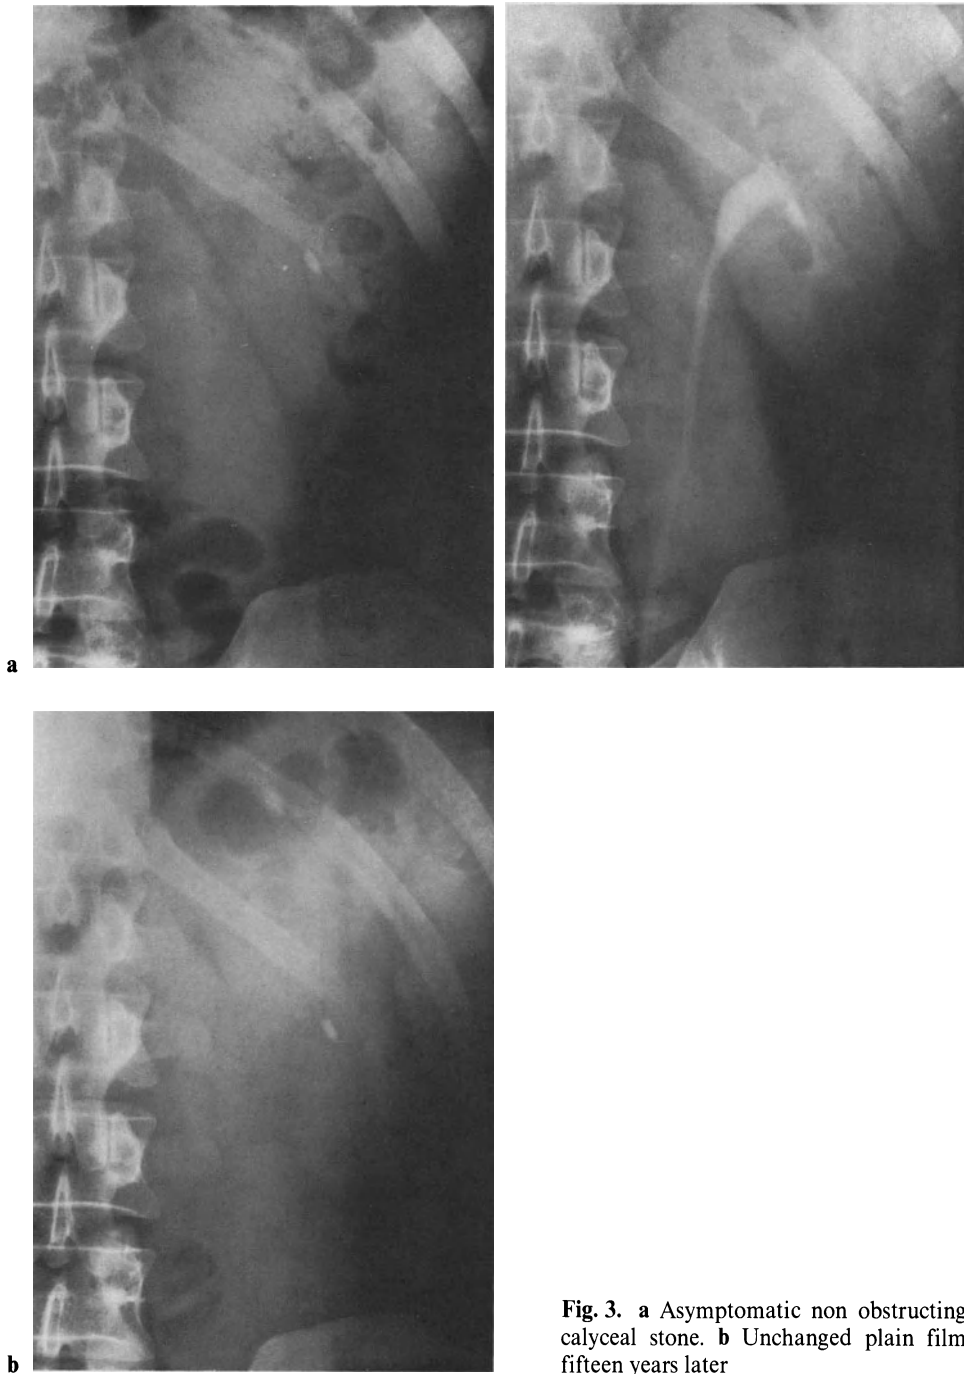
a Asymptomatic non obstructing calyceal stone. b Unchanged plain film fifteen years later
